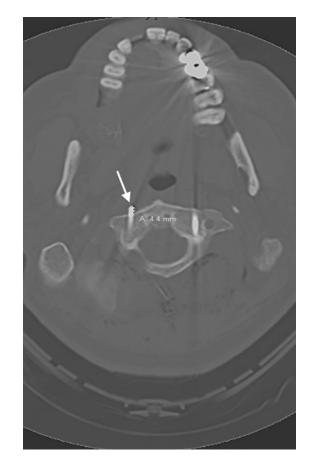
Postoperative axial CT image depicting the right C1 screw 4 mm beyond the cortical edge of the C1 arch (white arrow).
